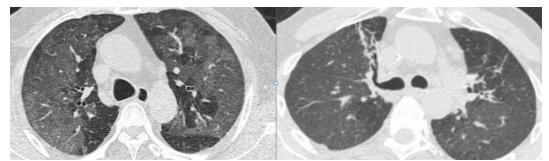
HRCT Thorax of a 56-year-old male patient initially shows multiple areas of ground glass attenuation (Image on the left). Repeat Axial HRCT shows patchy areas of fibrosis (Image on the right).
